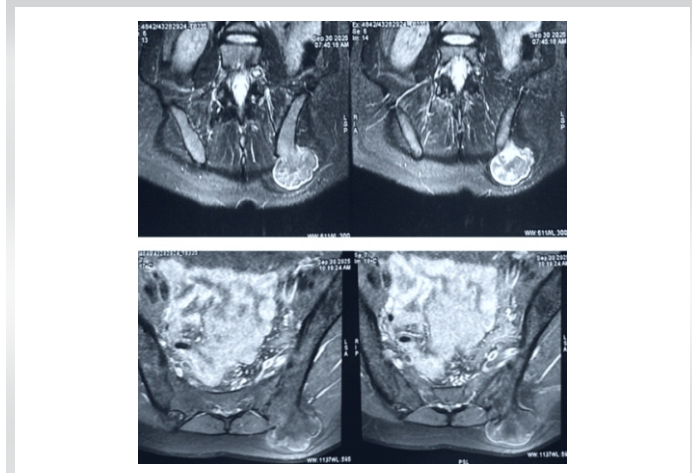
Magnetic resonance imaging showing well defined exostosis mass from posteroinferior part of left iliac bone.
